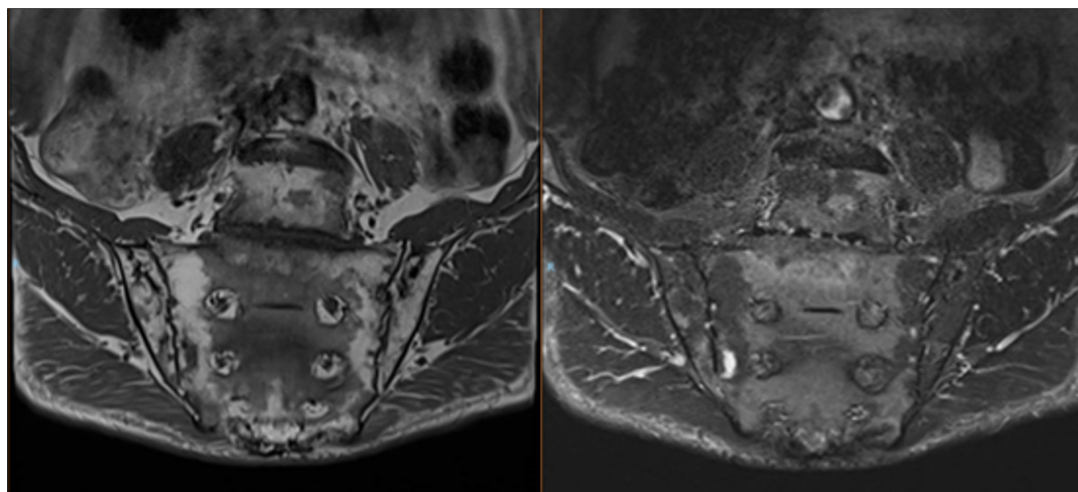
Right sacroiliitis on T1-weighted (left) and T2-weighted (right) MRI before treatment of WD, Whipple's disease.
